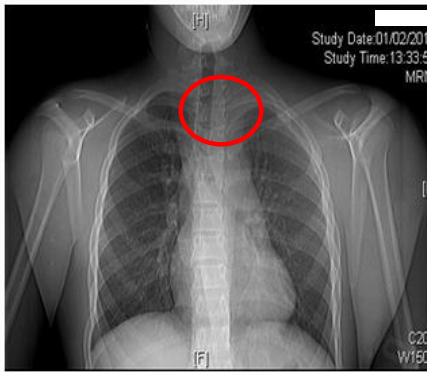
Radiography shows sternoclavicular dislocation to the left side.
